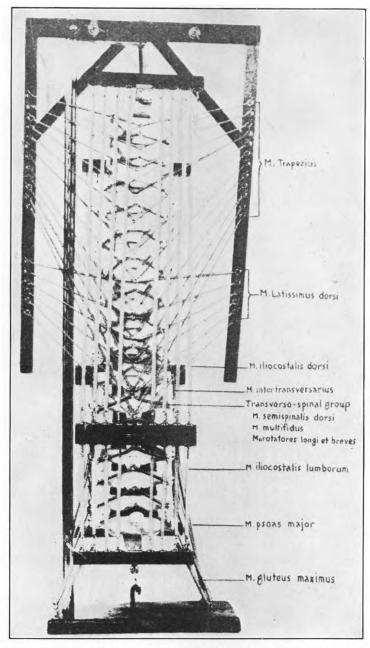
DORSAL ASPECT OF THE DYNAMIC MUSCLE-BONE BALANCE MODEL OF THE HUMAN SPINE.
